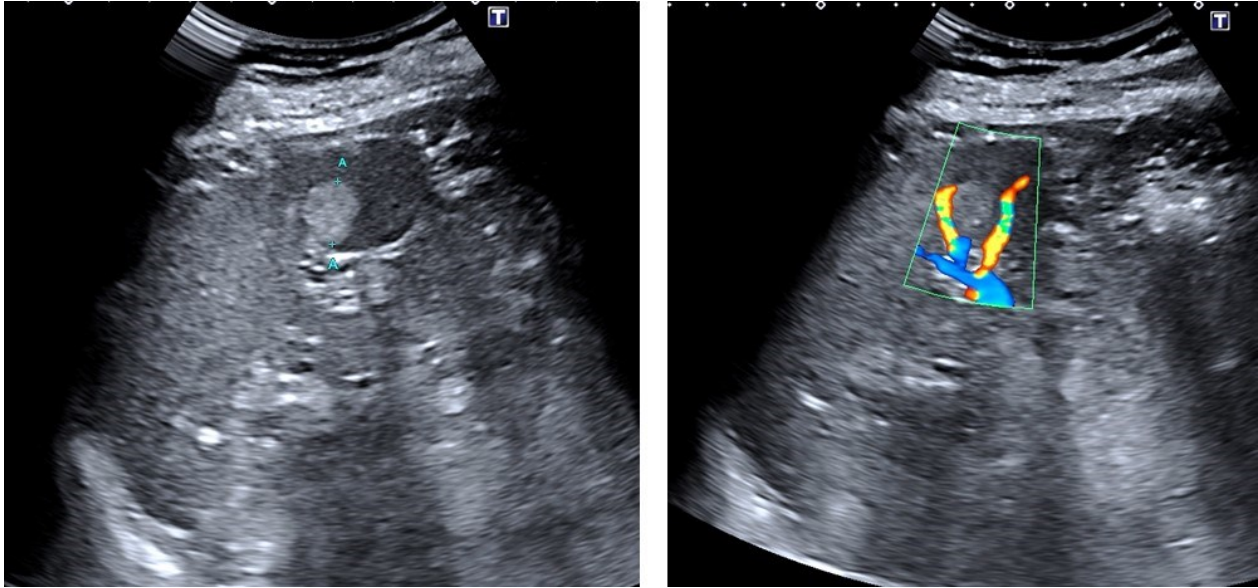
b.5. Splenic haemangioma. Focal round shaped hyperechoic lesion in the spleen, with sharp borders (lef panel), without detectable flow on Doppler examination (right panel)..
